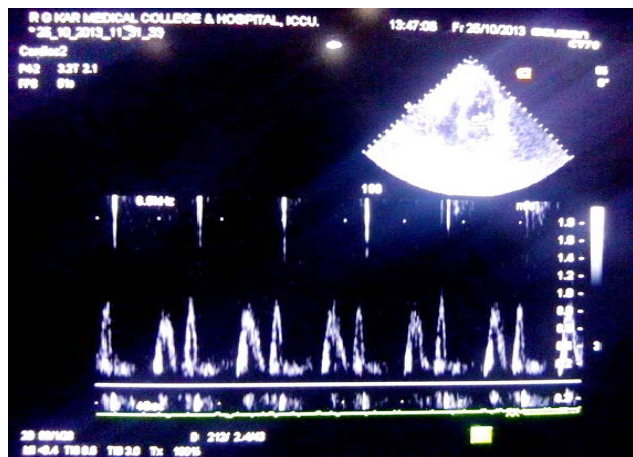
Echocardiography of RA patients of a case in our study showing diastolic dysfunction with decreased E/A ratio.
